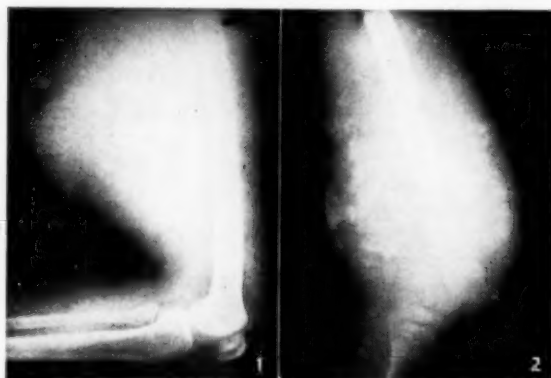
X-ray of a lipo-sarcoma of the thigh with a circumference of 105 cm.
